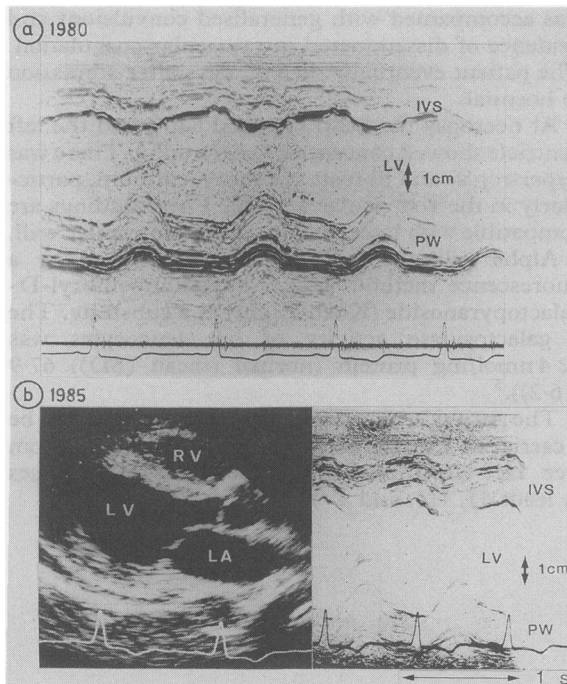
An M mode echocardiogram taken in 1980 (a) and a cross sectional and M mode echocardiogram taken in 1985. LA, left atrium; LV, left ventricular cavity; IVS, interventricular septum; PW, posterior wall; RV, right ventricular cavity.
